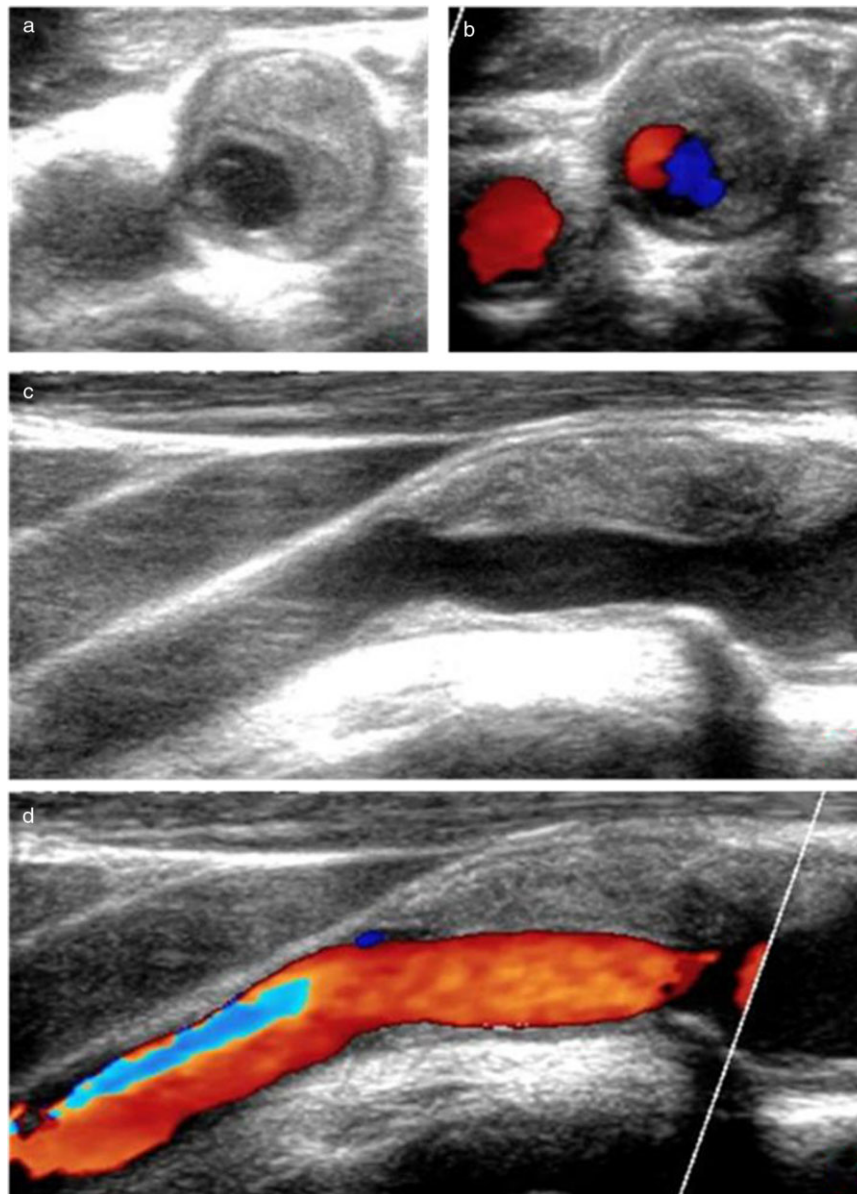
Transverse (a, b) and longitudinal (c, d) ultrasound images of the internal carotid artery in B-mode (a, c) and color-coded (b, d). Images are from the same patient as Fig. 2.
